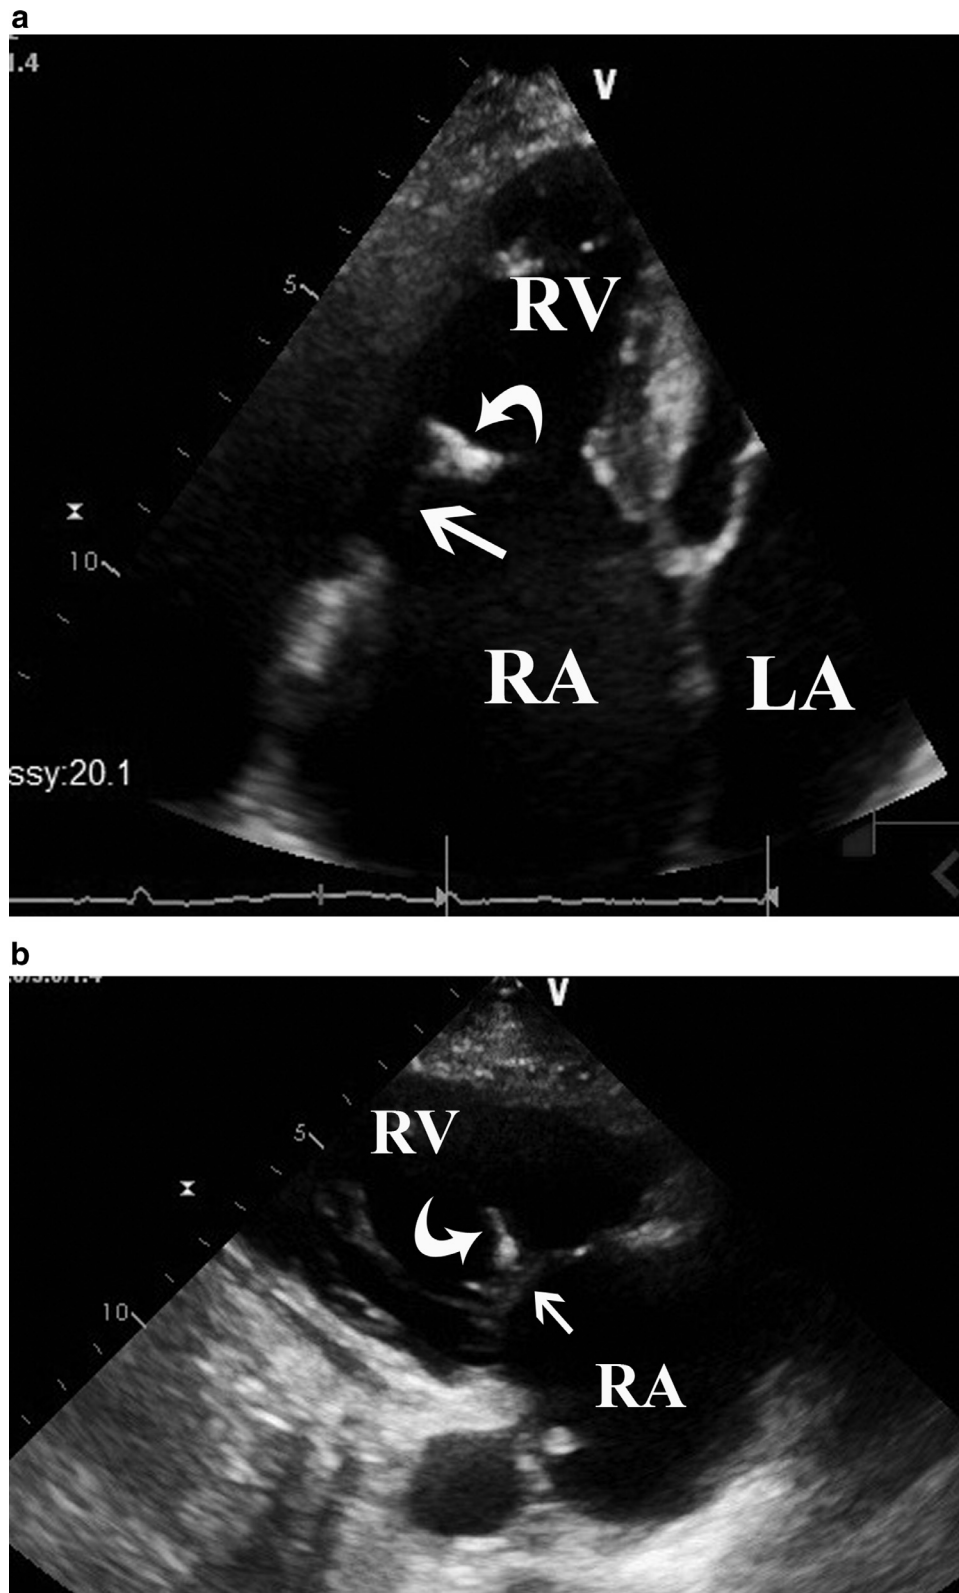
Images from transthoracic echocardiography in a 75-year-old woman with calcification of tricuspid valve chordae tendinea. 4-chamber view (a) and 2-chamber view (b) show an echogenic focus (curved arrow) attached to the ventricular side of the tricuspid valve (straight arrow). RA = right atrium; RV = right ventricle; LA = left atrium.
